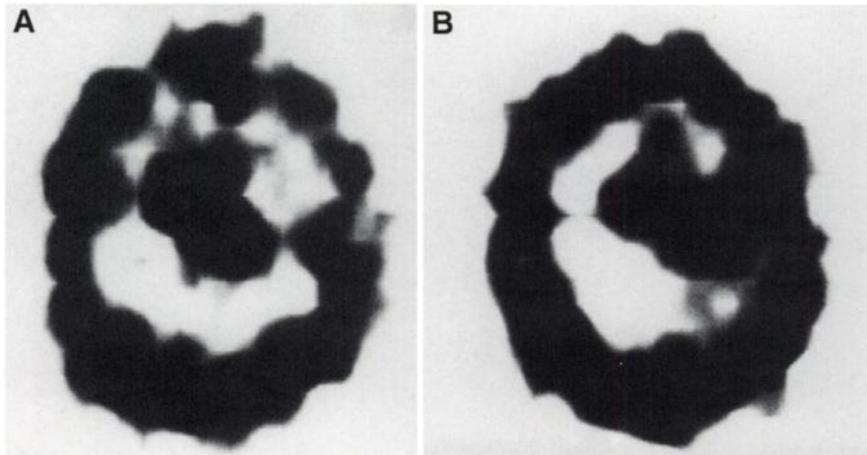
Low-grade tumor patient (22-y-old woman) with headache and dimness of vision for 2 mo. CT scan showed glioma in left ventricle of brain. (A) Early SPECT brain image shows high uptake of radioactivity (uptake index = 2.11). (B) Delayed SPECT brain image (uptake index = 1.26) shows lower uptake of radioactivity in same area as in (A). Retained index = 0.84. Pathologic examination revealed astrocytoma (grade II).
